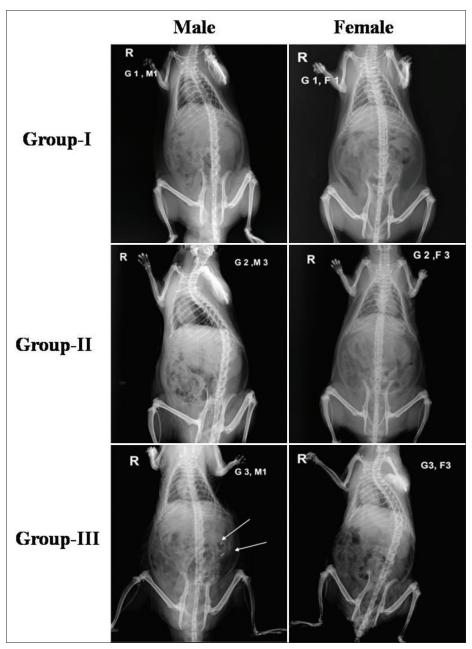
Effect of Kalsiwin on kidney X-ray analysis
